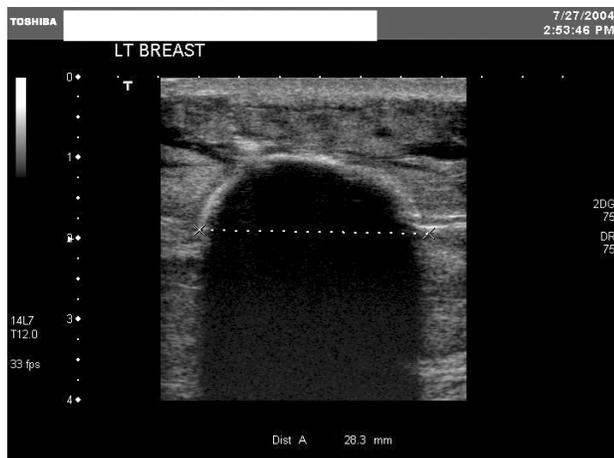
A. Ultrasound demonstrating Cryoprobe placement within target lesion.
